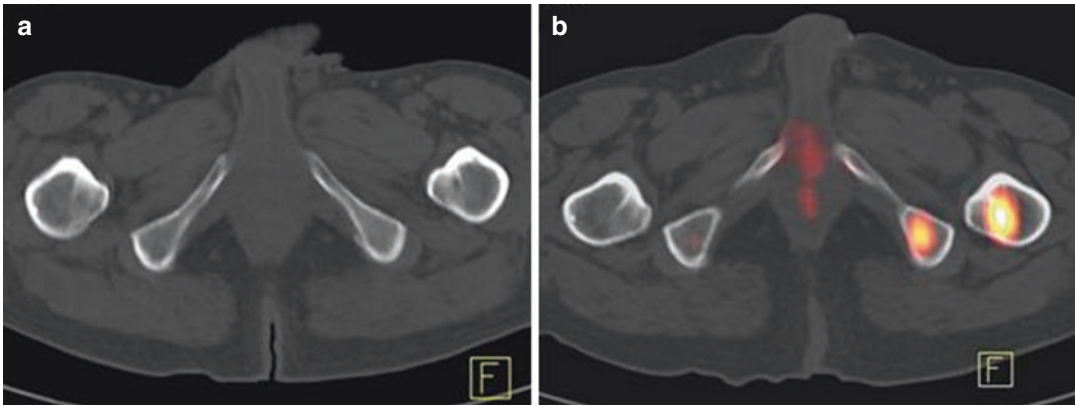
Metastases from cutaneous melanoma at the left ischium and at the left femur on PET-CT images (b), not obvious on CT (a)
